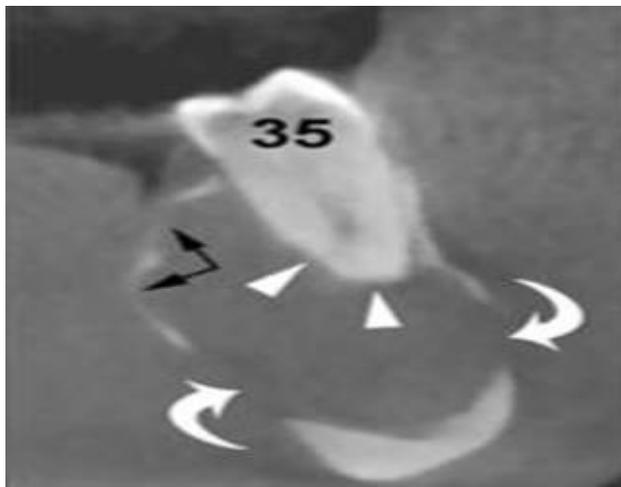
Cross- sectional CBCT images show an OKC with well-defined (white arrow) and lobulated margins (black arrow) located in the interforaminal region of the mandible^[18].
